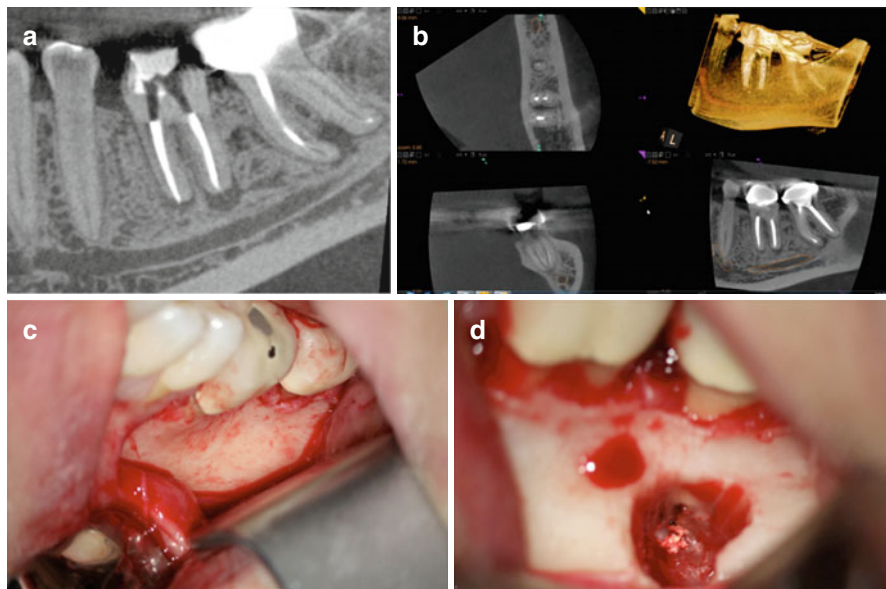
CBCT sagittal view of tooth #18 that was referred for periapical microsurgery (a). CBCT of the axial, coronal, sagittal views, and 3D rendering demonstrating the proximity of the IAN to the mesial root of tooth #18 (b). Clinical picture after surgical flap reflection showing the buccal cortical plate (c). Osteotomy and resection of the mesial root (d)
